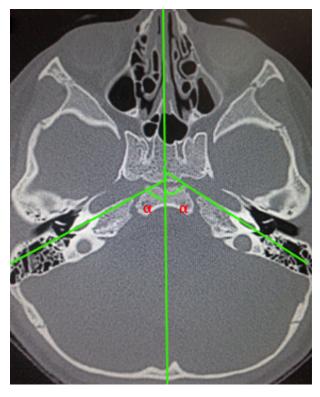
Axial computed tomography scan demonstrating how angle α was measured.
